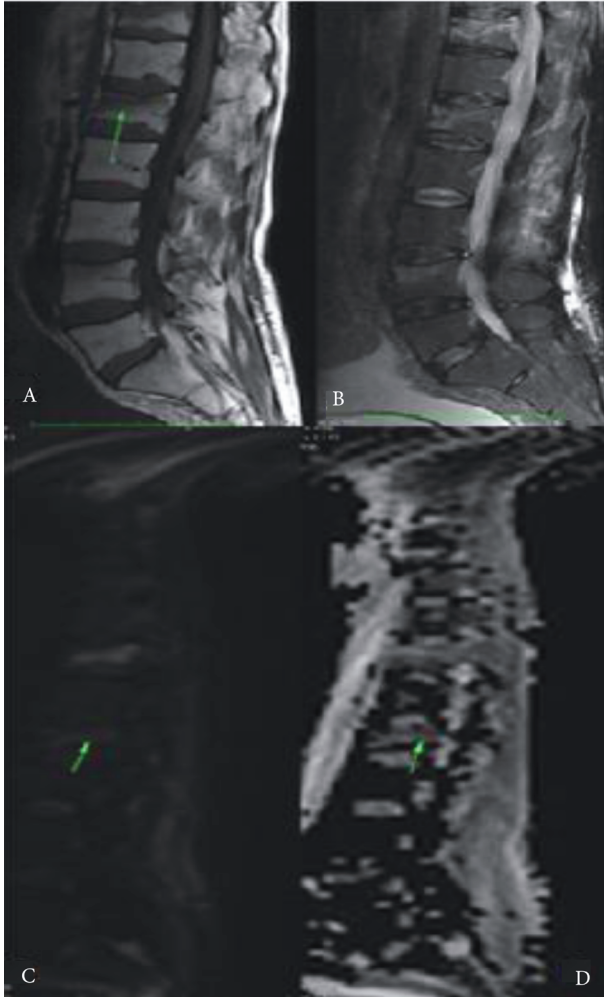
A-D. Malignant-appearing compression fractures, most prominent at the L1 vertebra of a 54-year-old patient without a known primary malignancy. The T1-weighted axial MR image (A) shows hypointensity in the lesion (arrow). The T2-weighted axial MR image (B) shows hyperintensity in the lesion (arrow). DWI (C) shows hyperintensity in the lesions (arrow). The ADC map (D) shows hypointensities in these lesions due to restricted diffusion (arrow). The mean ADC value is $0.81 \times 10^{-3} \text{ mm}^2/\text{s}$ from the ADC measurement of the lesion at L1, supporting a malignant pathology.
